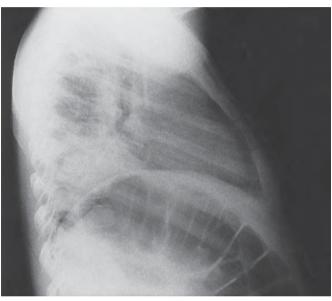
Posteroanterior (A) and lateral (B) chest radiographs of a 6-year-old child with acute nonlymphocytic leukemia and aspergillosis.
